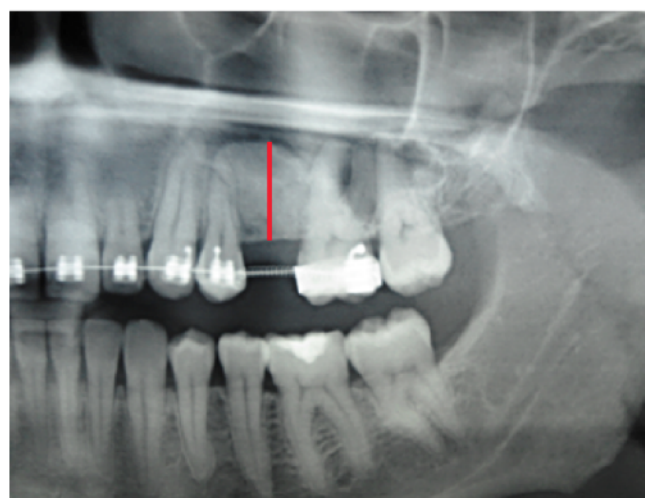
Postoperative radiograph after grafting surgery. The line corresponds to the final height of alveolar edge six months after grafting.
